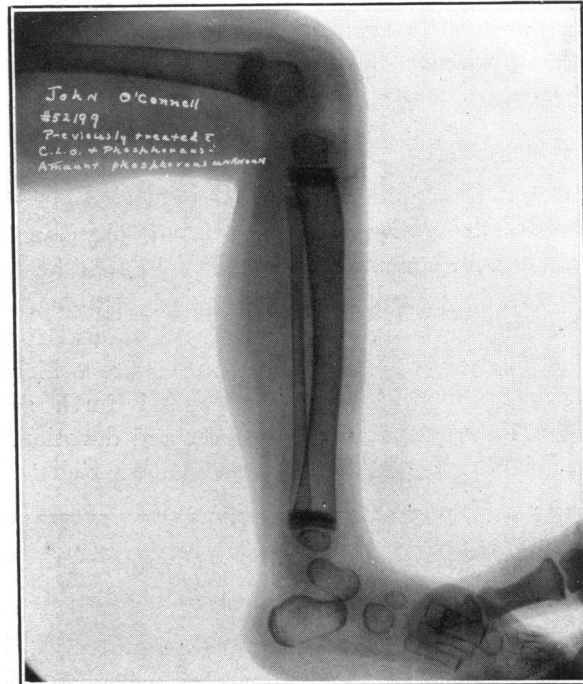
J. O. X-ray photograph of leg of same child as in Fig. 3 (focal distance the same). One can see that the rate of growth is fastest at the lower end of femur, less fast at the ends of the tibia and, by comparing leg and arm, that the growth at the ends of the tibia is slightly in excess of that at the lower ends of the radius and ulna.
